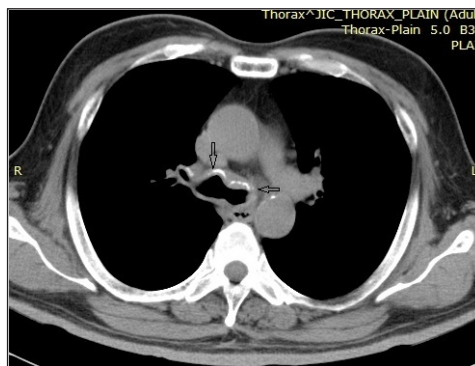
Computed tomography of thorax showing circumferential calcification of the trachea-bronchial tree, and patchy consolidation in bilateral lower lobe areas
